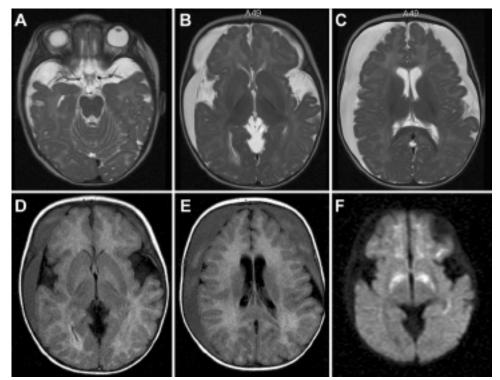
Axial MR images of the brain. A–C: A series of T_2 -weighted images demonstrating subdural collections in the middle cranial fossa (A), bilateral prominent opercular cisterns (B), and large bilateral chronic subdural collections (C) causing moderate underlying mass effect. D and E: Two T_1 -weighted images showing bilateral chronic SDHs. The opercular cisterns remain prominent with cerebrospinal fluid (D). F: A diffusion weighted image demonstrating diffusion restriction in the bilateral globus pallidus and frontal white matter. These unifying features of bilateral subdural collections, batwing opercular cisterns, abnormal signal intensity within the globus pallidus, and patchy white matter signal abnormalities support the diagnosis of GA1.
